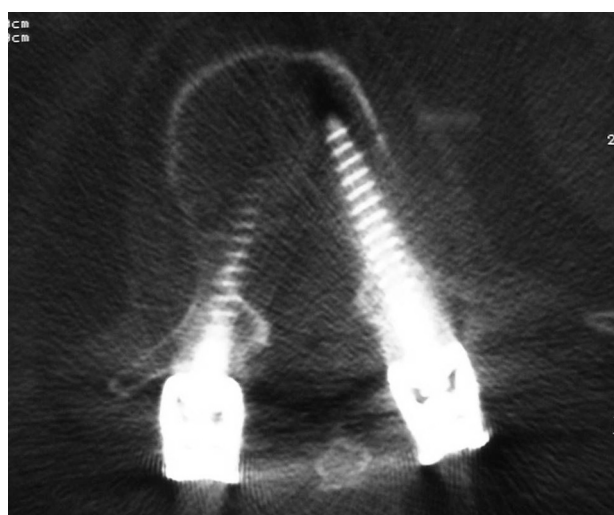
Right screw encroached the medial pedicle cortex of L1 at axial CT scan. It was evaluated as “acceptable” placement according to Youkilis’ criteria.
